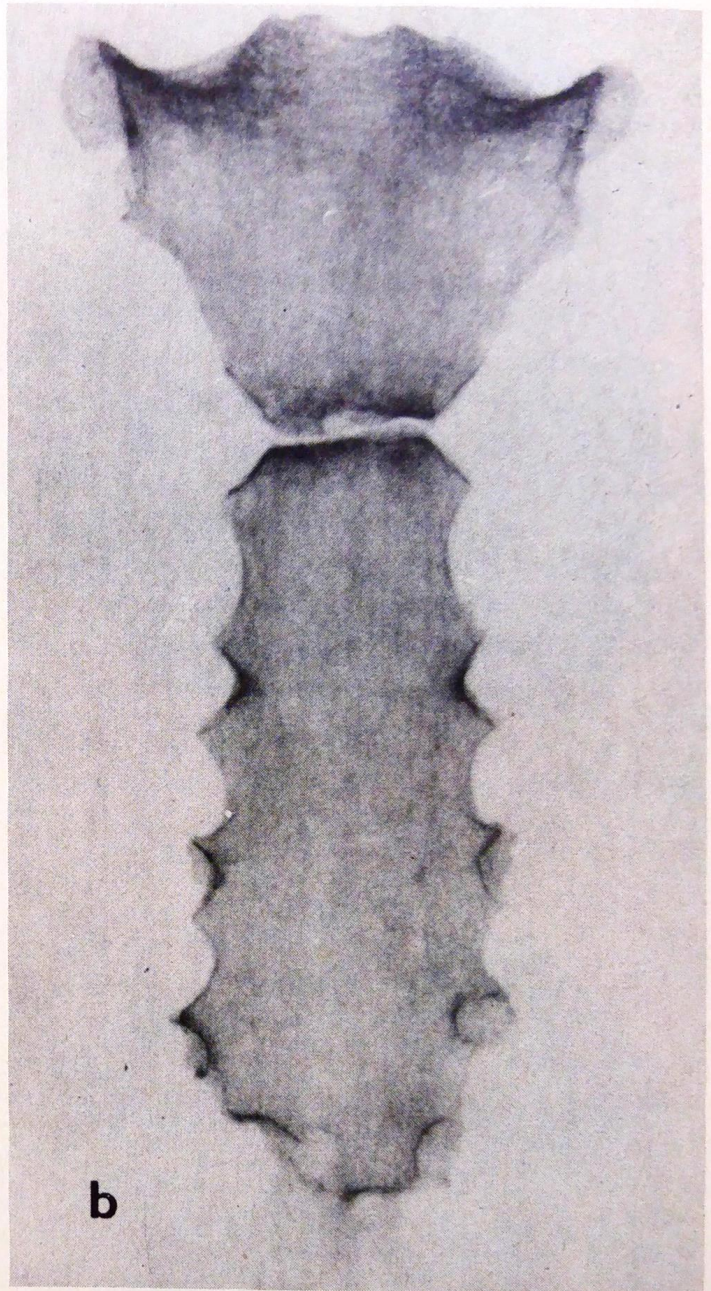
a) Sternum. Manubrium does not adhere to the corpus, b) X-ray (photo by A. Klein).
